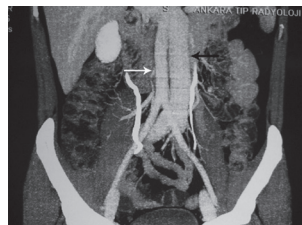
Coronal maximum intensity projection image obtained with multidetector row CT shows the left sided inferior vena cava (black arrow). White arrow i
